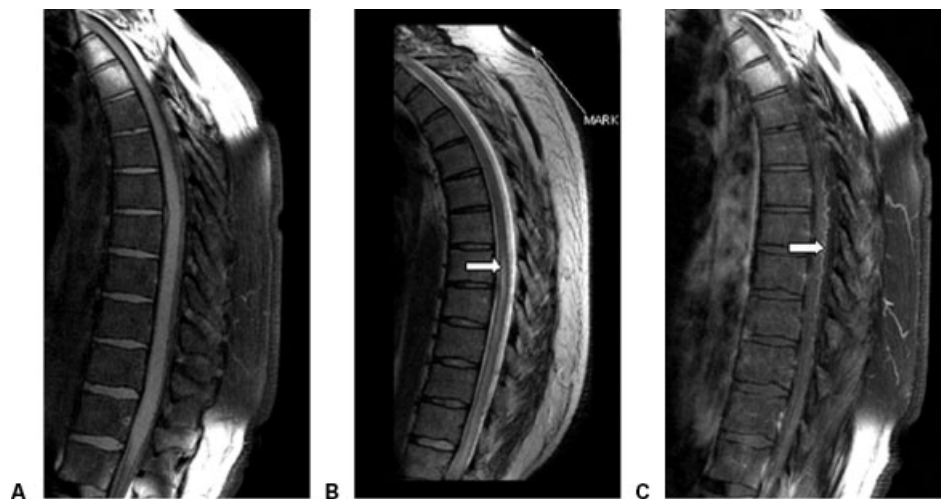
A 49-year-old man who presented with acute myelopathy. (A) T1-weighted image shows no definite abnormality. (B) T2-weighted image shows hyperintense longitudinally extensive lesion. (C) Gadolinium-enhanced T1-weighted image reveals dilated blood vessels on the surface of the cord.
